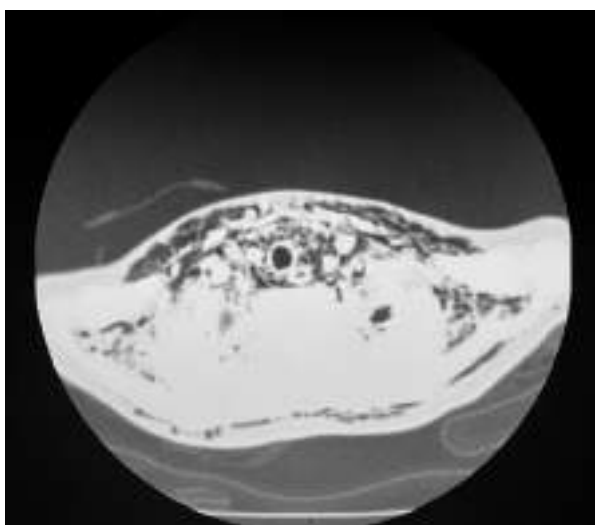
CT of the upper part of the chest shows chest wall emphysema and a smaller partial pneumothorax in the apex of the left lung
